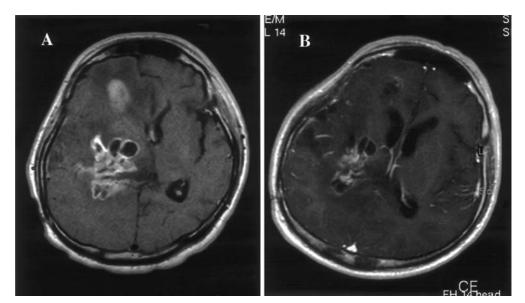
Recurrent anaplastic astrocytoma in right thalamic lesion, before (A) and after (B) one cycle of temozolomide. Gadolinium-enhanced magnetic resonance imaging reveals a partial response
